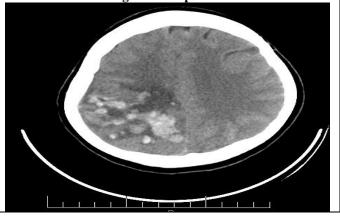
CT head showing left occipital bleed with mass effect and SAH on right fronto-parietal lob
